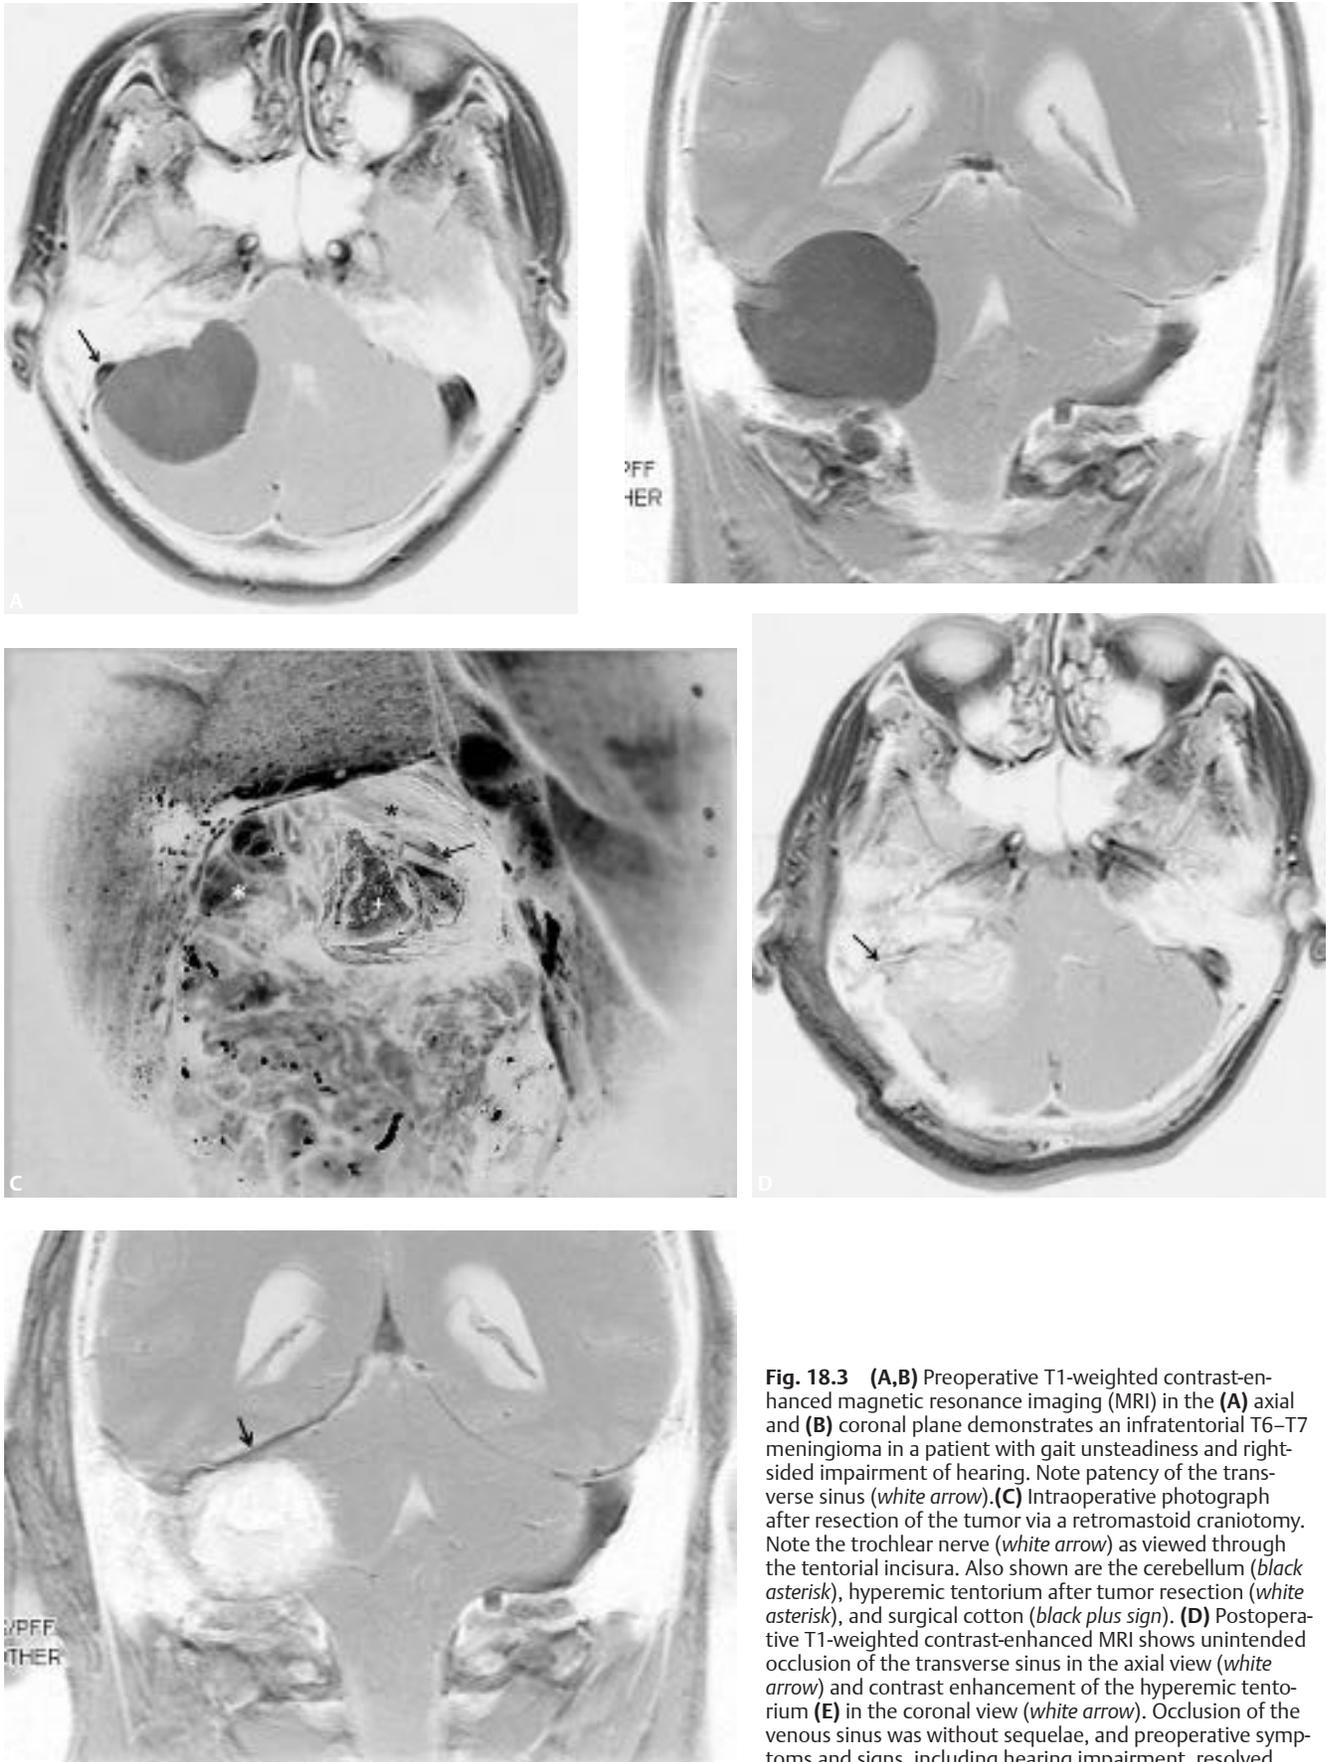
(A,B) Preoperative T1-weighted contrast-enhanced magnetic resonance imaging (MRI) in the (A) axial and (B) coronal plane demonstrates an infratentorial T6–T7 meningioma in a patient with gait unsteadiness and right-sided impairment of hearing. Note patency of the transverse sinus (*white arrow*). (C) Intraoperative photograph after resection of the tumor via a retromastoid craniotomy. Note the trochlear nerve (*white arrow*) as viewed through the tentorial incisura. Also shown are the cerebellum (*black asterisk*), hyperemic tentorium after tumor resection (*white asterisk*), and surgical cotton (*black plus sign*). (D) Postoperative T1-weighted contrast-enhanced MRI shows unintended occlusion of the transverse sinus in the axial view (*white arrow*) and contrast enhancement of the hyperemic tentorium (E) in the coronal view (*white arrow*). Occlusion of the venous sinus was without sequelae, and preoperative symptoms and signs, including hearing impairment, resolved.
